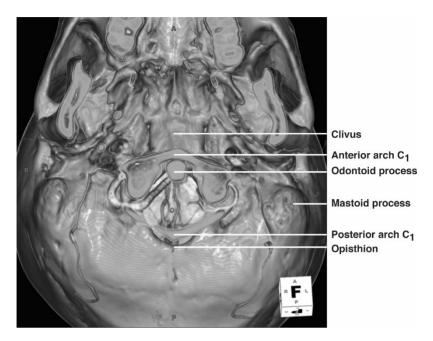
Inferior view of the craniocervical junction via 3D reconstructed CT angiogram. Note the occiput posteriorly, the dens anteriorly and the atlas with left and right vertebral arteries leaving the transverse foramina to course over the sulcus for the vertebral arteries.
